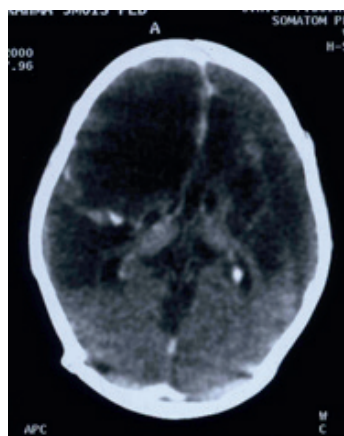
Axial CT-Scan of the head with contrast enhancement on 3 months: Bilateral large hypodense lesions of the middle cerebral arteries
